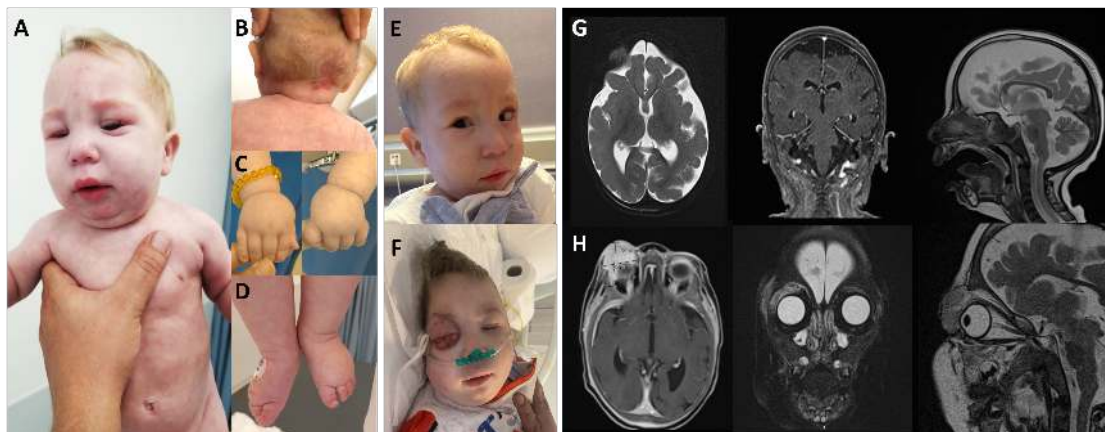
Clinical findings of index 3 at 10 months of age show (A) mild facial dysmorphism comprising high forehead, bilateral microphthalmia, strabismus, nystagmus, long philtrum, micrognathia, low-set ears and short neck, (B) cutis marmorata, capillary hemangiomas, (C-D) edema on the dorsum of hands and feet. Phenotype of the index at (E) at 1 year 8 months of age, (F) at 3 years 4 months of age, further shows the mass on the right upper eyelid. (G) cranial MRI at 1 year 11 months of age showed severe cerebral atrophy and pachymicrogyric areas mainly on parietal lobes. (H) orbital MRI at 3 years 4 months of age demonstrated an extraconal mass of 30x26x21 mm in size that surrounds the anterior and lateral parts of the right bulbous oculi and extending to the preseptal area.
